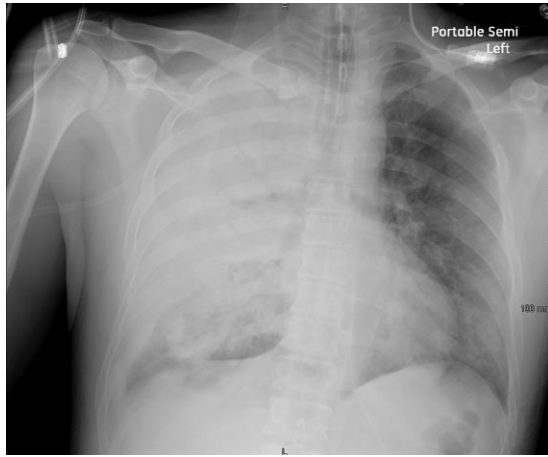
Portable chest radiograph for case patient 1 from hospital day 3 showing dense consolidation in the right lung, greatest in the mid and upper chest. Air bronchograms were present. Pleural fluid was possibly present, and empyema was a consideration. Patchy, milder infiltrates were seen in the left lung.
